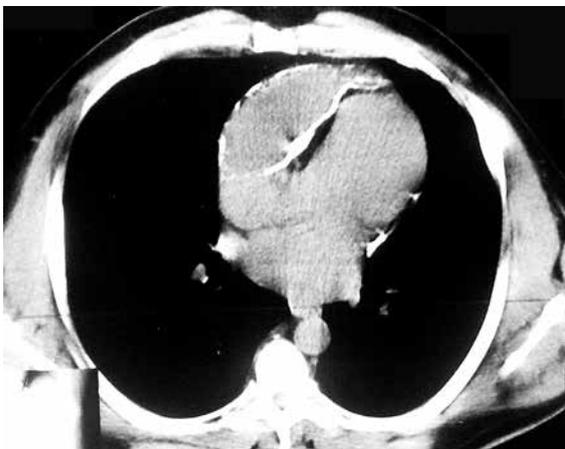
Image of thorax computed tomography with venous contrast showing voluminous liquid collection with calcified borders between the sternum and right ventricle. Source: personal archive.
